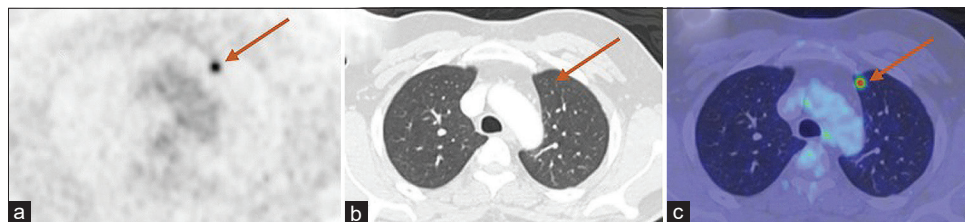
MIP image (a), CT scan axial image in lung window (b), and axial fused image in lung window (c), from FDG PET/CT of 51-year-old man, showed an increased metabolism in anterior segment of left upper lobe without any abnormality in CT scan (brown arrow), suggestive of hot spot sign.
